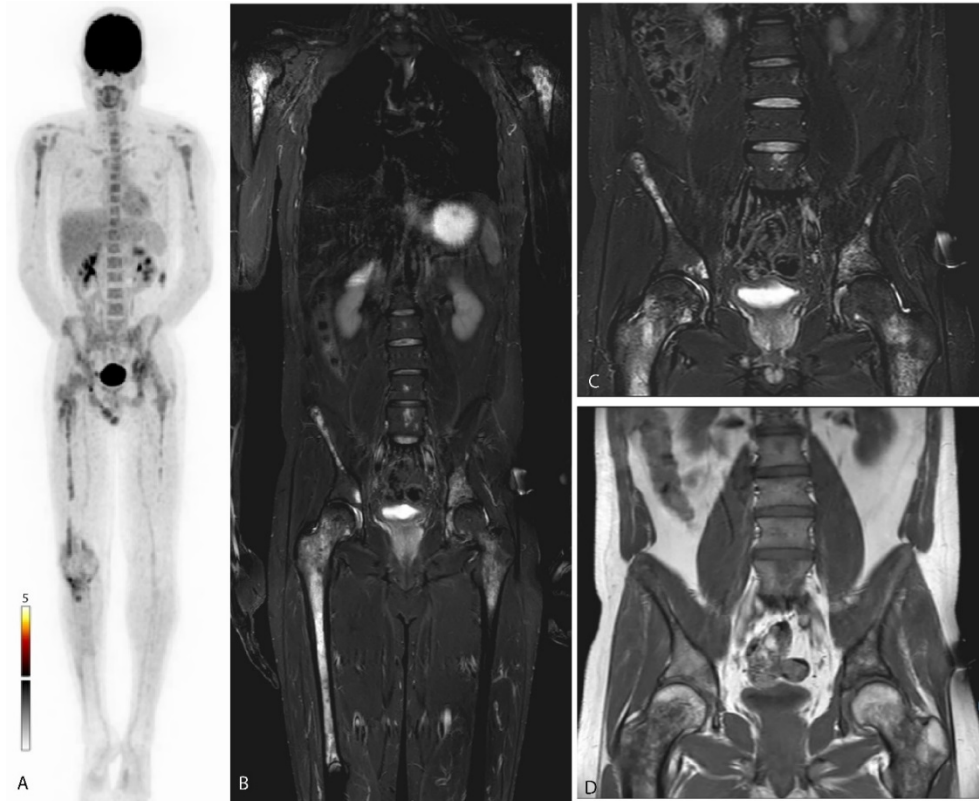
False-positive lesions on <sup>18</sup>F-FDG PET-CT.
